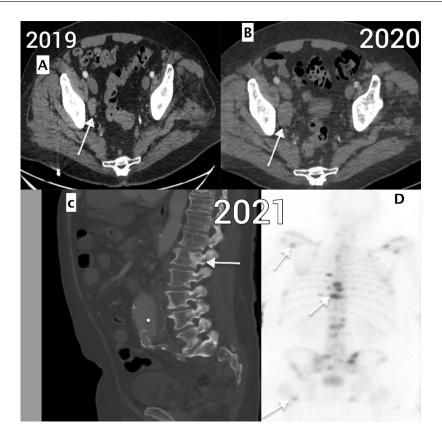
A: Contrast enhanced CT scan, axial sections, done in 2019. It shows enlarged right pelvic side wall node (white arrow). B: Contrast enhanced CT scan, axial sections, done in 2020. It shows the right pelvic side wall node has increased in size (white arrow). C: Bone window, Sagital reconstruction of Contrast CT done in year 2021 showing infrarenal aortic aneurysm (white dot) and sclerotic bone metastasis (white arrow). D: Bone scan of the patient done in 2021, showing uptake in spine, femur and scapula (white arrows) confirming metastasis.
